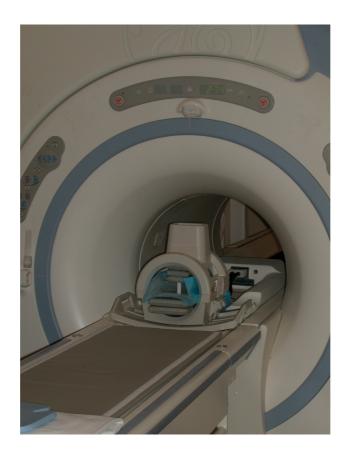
1.5 T Clinical MRI-Scanner
